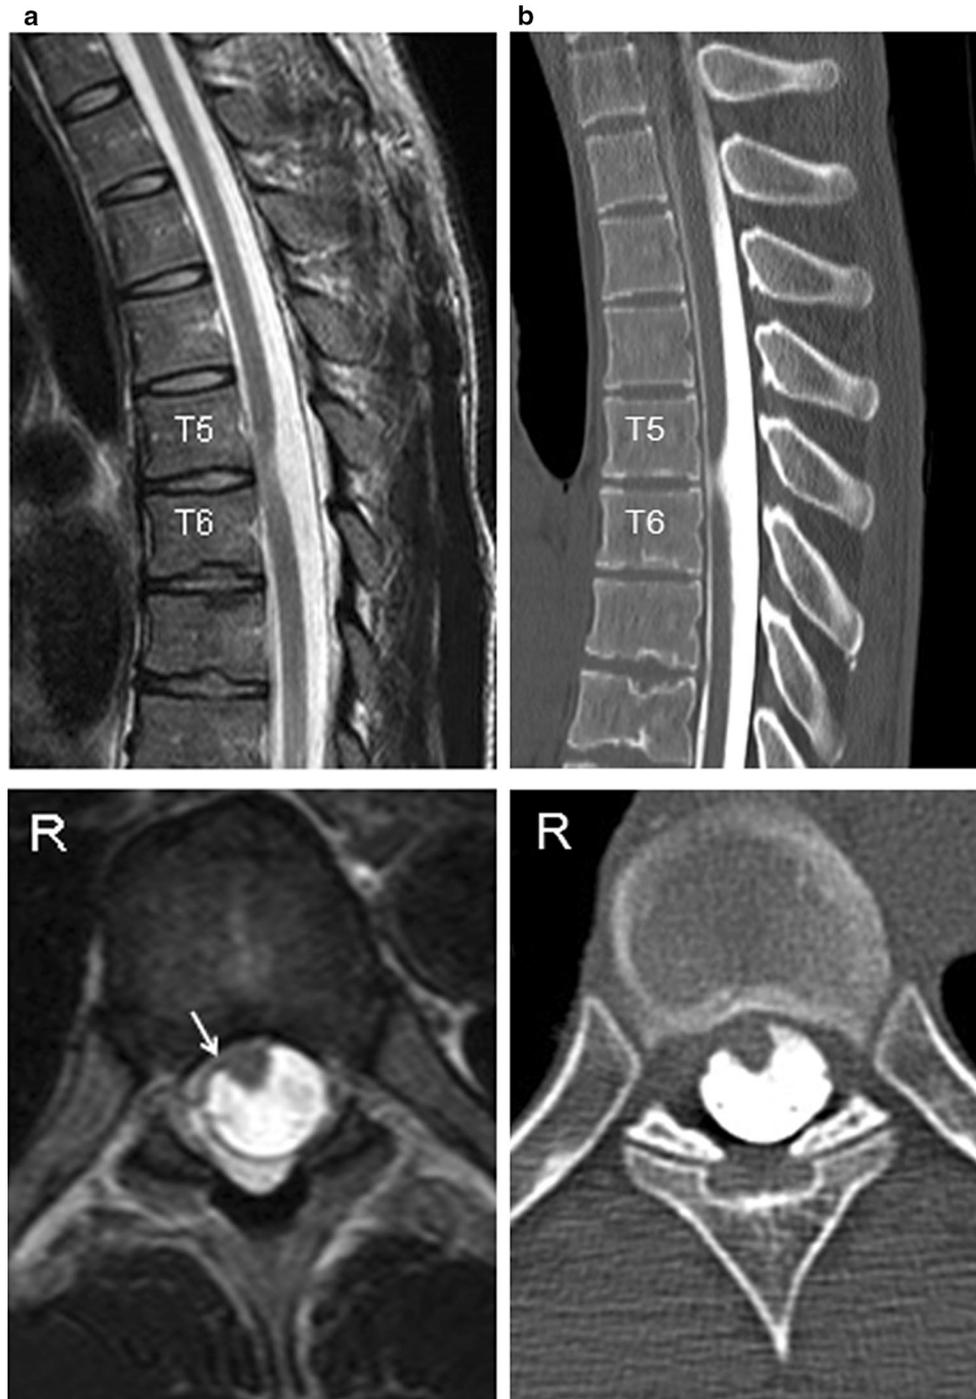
Preoperative 3-tesla T2-weighted MRI (a), and CTM obtained just after contrast injection (b). Sagittal- (upper row) and axial images at the T5–6 intervertebral level (lower row) demonstrate ventral displacement of the spinal cord with an acute angle at the T5–6
